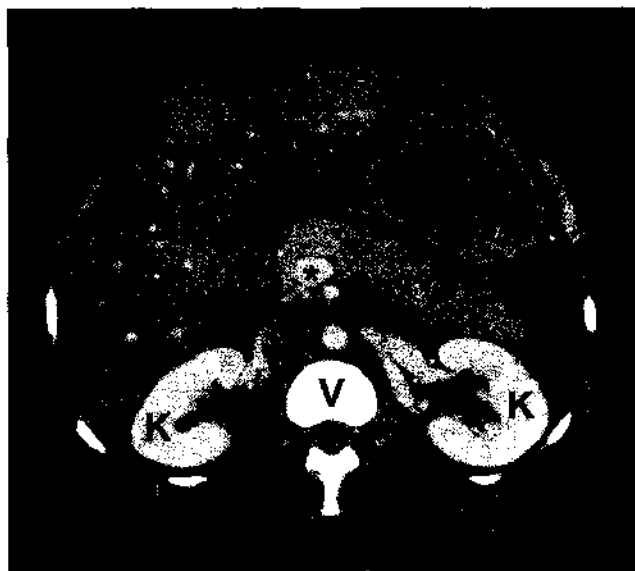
CT scan. This axial view reveals relationships of the pancreas (P) to neighboring major structures: liver (right lobe, RL, and left lobe, LL), stomach (St), kidneys (K), vertebral body of lumbar vertebra (V), portal confluence (*), and inferior vena cava (arrow). The body of the pancreas crosses the midline and the tail of the pancreas lies in close proximity to the spleen (not seen) on the left. The distal part of the body and the tail of the pancreas are anterior to the left kidney. The body of the pancreas is anterior to the inferior vena cava and the vertebral body. Note that the pancreas is posterior to the stomach and left lobe of the liver. The portal confluence, visible in the head of the pancreas, is in close approximation to the right lobe of the liver.
